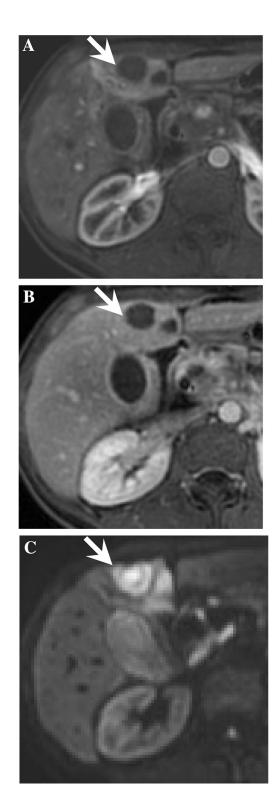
LR-M in a 54-year-old man with hepatitis B virus cirrhosis. Contrast-enhanced MRI in the arterial (A) and delayed (B) phase images show a rim enhancing mass (arrow) in the medial left hepatic lobe, and diffusion-weighted (C) images show a targetoid appearance (arrow). This lesion was found to be metastatic pancreatic adenocarcinoma at biopsy.
